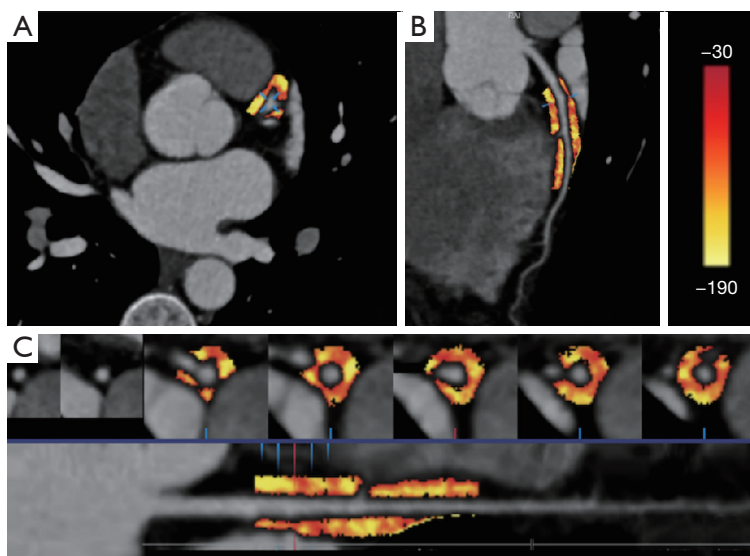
A 28-year-old female TAK patient underwent coronary artery CTA examination due to chest tightness and pain. The coronary CTA image and MPR of the coronary artery showed no thickening of the left main artery and left anterior descending branch walls, no stenosis of the lumen, and unobstructed artery lumen, indicating a healthy coronary artery. TAK, Takayasu arteritis; CTA, computed tomography angiography; MPR, multiplanar reformation.
